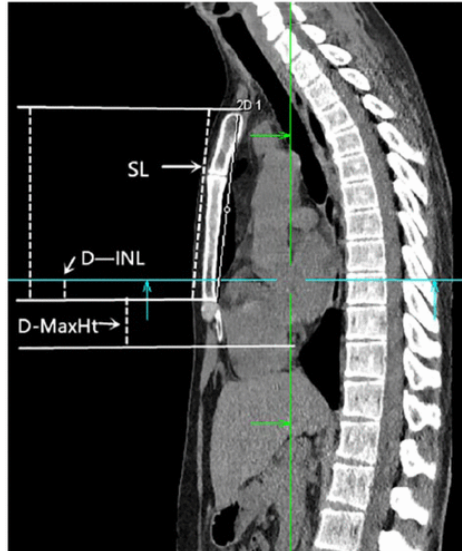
The sagittal image of chest-computed tomography. Adapted from Jiang et al. Hong Kong J. Emerg. Med. 2020; Vol.27(4) 197-201 [57].
